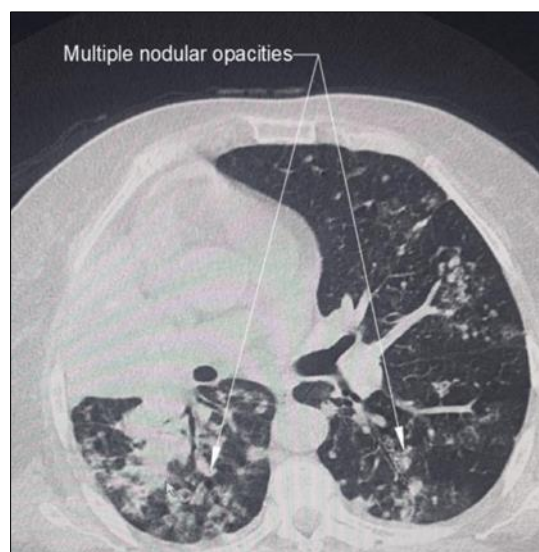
Thoracic CT Scan: multiples nodular opacities
